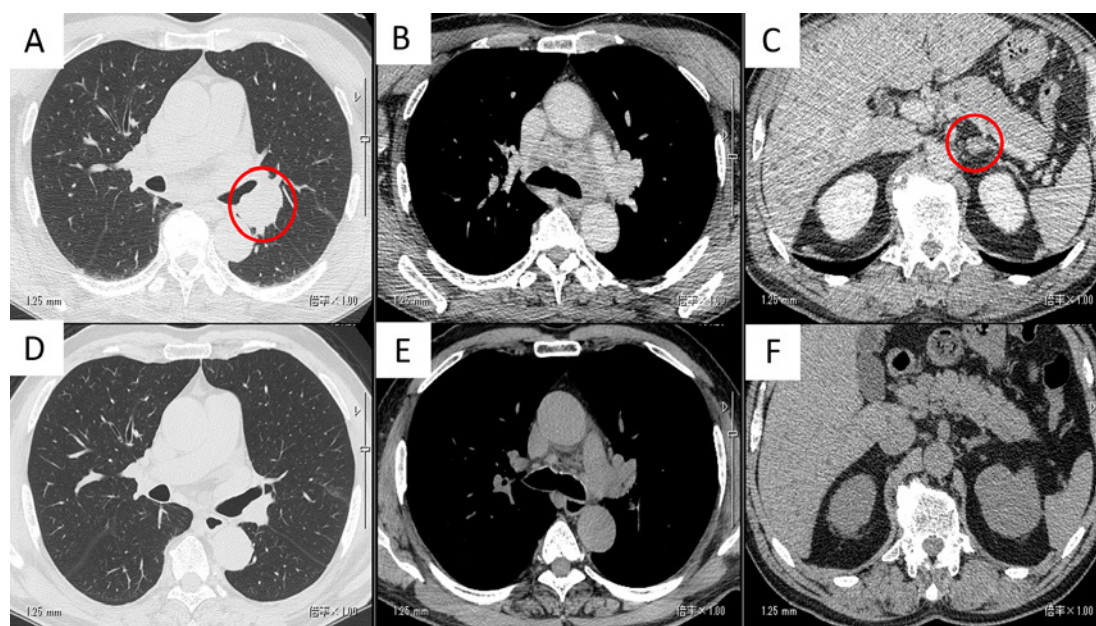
Chest computed tomography scans. A–C Performed before the initiation of pembrolizumab. D–F Performed on day 196 (after 9 cycles of pembrolizumab) after the initiation of pembrolizumab. A A 2.2-cm tumor in the lower lobe of the left lung was seen (red circle). The primary lesion was observed. B Mediastinal lymph node metastasis was observed. C Left adrenal metastasis was observed. D, E The size of the primary lesion and mediastinal lymph node was reduced. F The left adrenal metastasis had disappeared.
